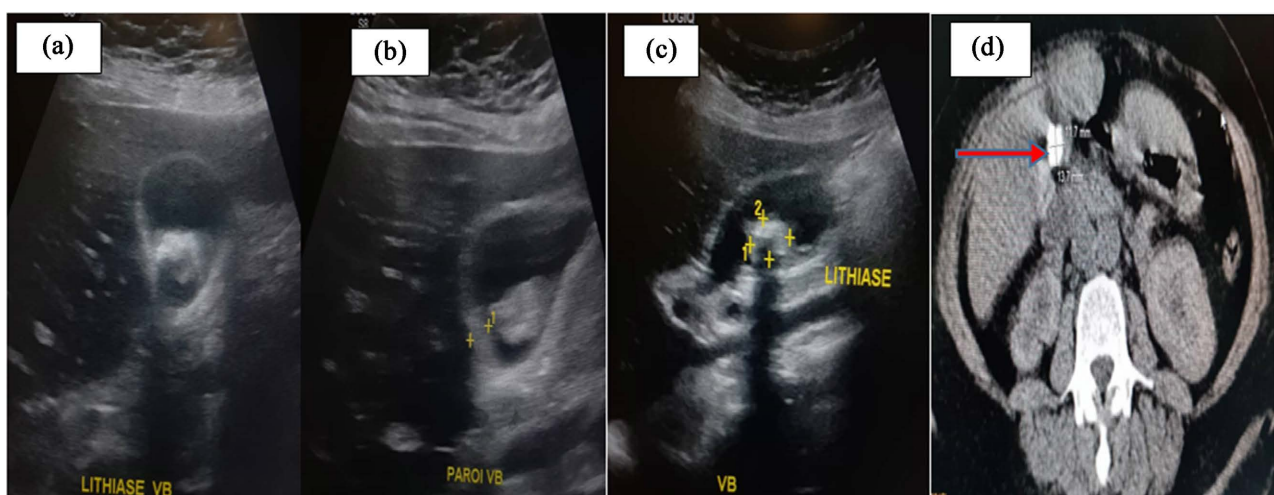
Abdominal ultrasound (a)-(c) and computed tomography (d) images showing acute lithiasic cholecystitis, (a) Enlargement of the gallbladder with hyper echogenic material within it, (b) Thickening of the wall gallbladder, (c) Measurement of the gallstone and posterior cone of shadow, (d) Measurement of the gallstone on the CT scan.
